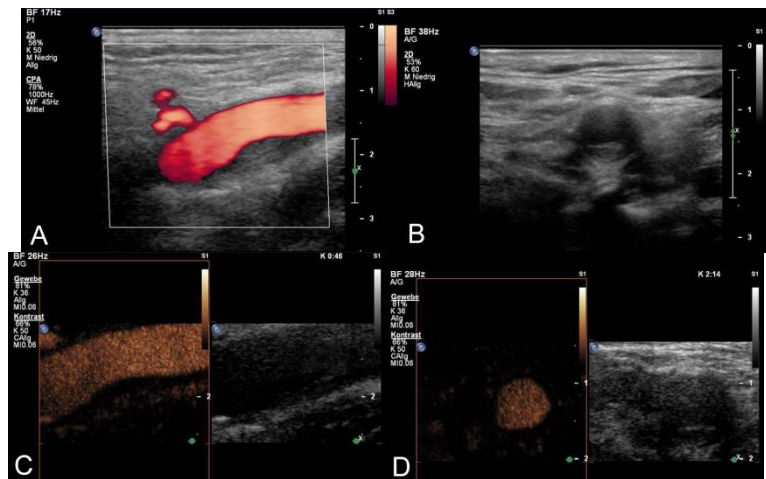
A 62-year old male patient with known aplastic anemia with thrombocytopenia (platelet count 18,000/microL) and no cardiovascular risk factors presented with acute pain starting 8 days ago located at the region of the left carotid bifurcation. He did not remember any previous trauma of the neck. B-mode ultrasound imaging using a 3-9MHz linear probe revealed an intraluminal hypoechoic thickening at the far wall of the left distal common carotid artery in the longitudinal (A) and cross-sectional view (B). No relevant stenosis of the carotid artery on power-Doppler ultrasound was found (A). After a bolus injection of 2.5ml Sonovue™ the lesion in the longitudinal (C) and transversal view (D) revealed no microbubbles within intraluminal lesion on CEUS and some adventitial vasa vasorum in the outer adjacent vessel wall suggesting a non-vascularized intraluminal lesion of the vessel wall. Based on the clinical presentation, the course with spontaneous decrease of the lesion after 3 month in the follow-up carotid ultrasound and no vascularization within the intraluminal lesion but vasa vasorum in the adjacent adventitia layer on CEUS, the diagnosis of a spontaneous vessel wall hematoma based on a hemorrhage within the vessel wall of the carotid artery was made.
